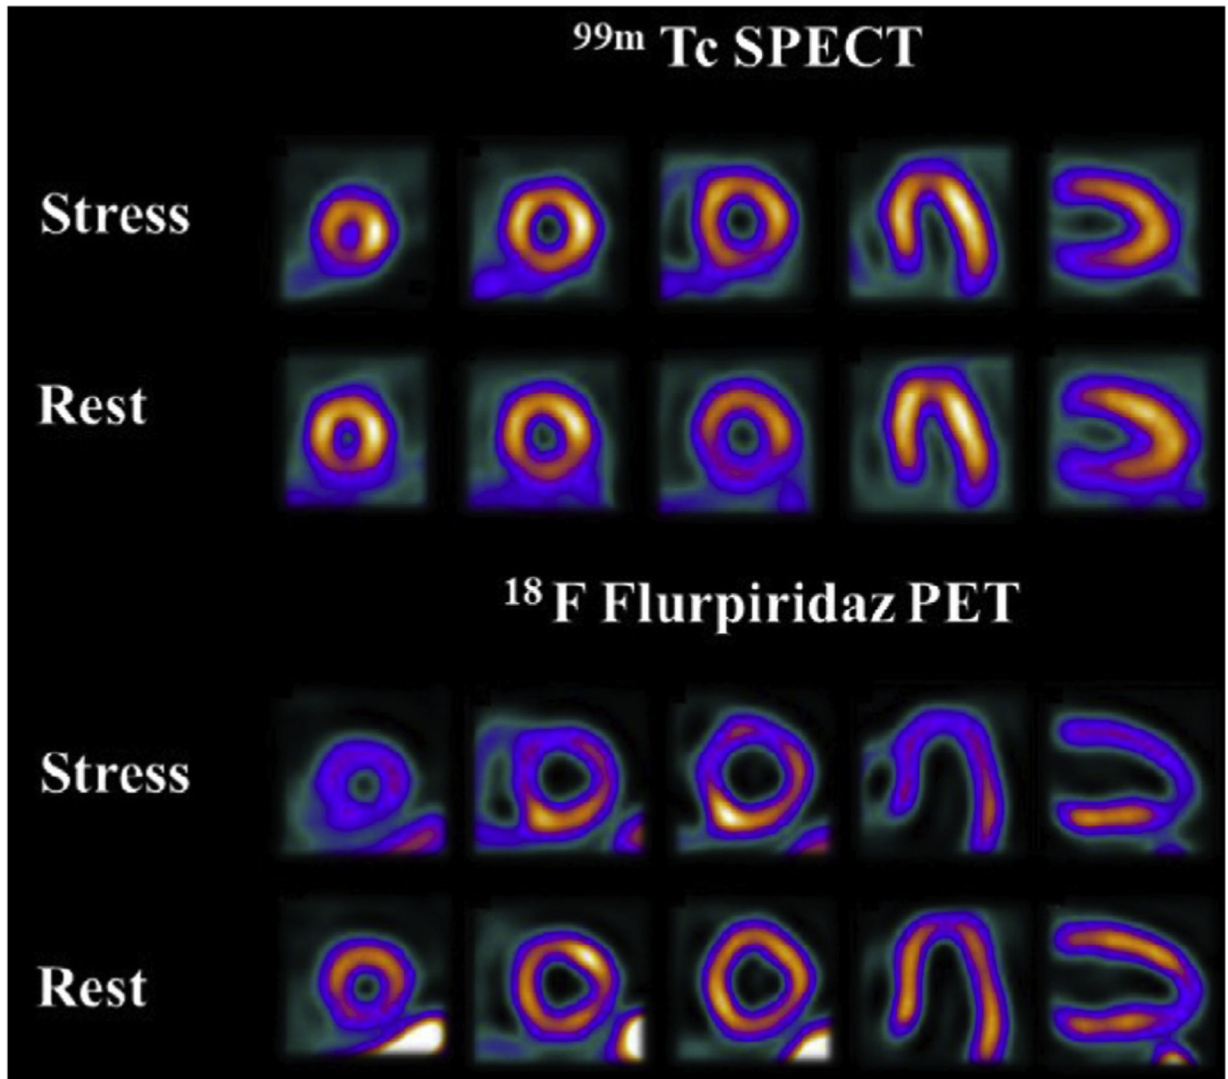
Rest and pharmacological stress SPECT and [¹⁸F]flurpiridaz PET images. This 82-year-old male patient without a history of myocardial infarction had 100% proximal obtuse marginal occlusion as well as 56% proximal and 80% distal left circumflex stenoses. Both studies are true-positive, but stress and rest perfusion defects in the lateral wall are more prominent and larger on PET than on SPECT images. (From Maddahi J, Lazewatsky J, Udelson JE, et al. Phase-III Clinical Trial of Fluorine-18 Flurpiridaz Positron Emission Tomography for Evaluation of Coronary Artery Disease. *Journal of the American College of Cardiology*. 2020/07/28/ 2020;76(4):391–401.)
